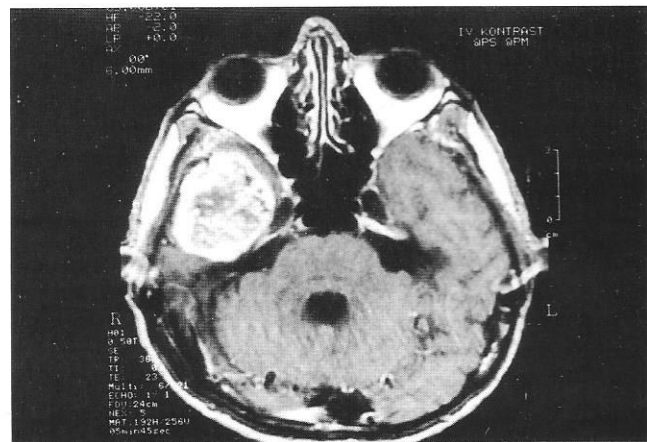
Magnetic resonance image showing a right temporal mass of 50 x 44 x 44 mm with peripheral contrast enhancement and central necrosis causing a midline shift of 11 mm.
